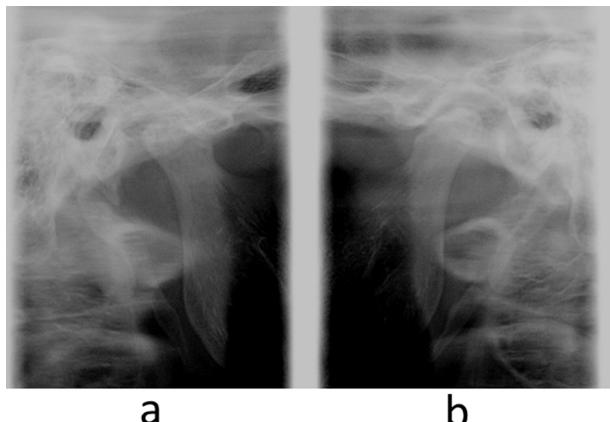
TMJ radiography using panoramic equipment in the intercuspal position after 25 years (2014.3.4). (a) Right TMJ, (b) left TMJ
